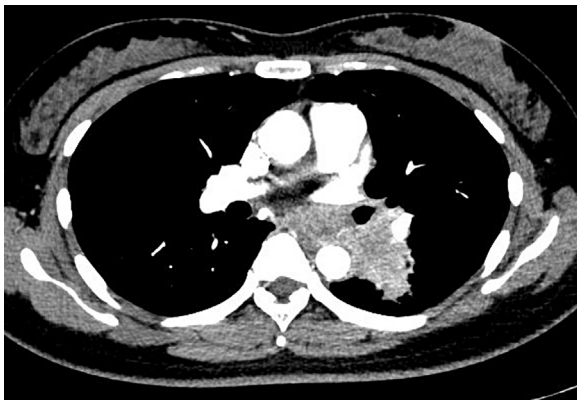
Enhanced computed tomography scan performed at the time of hospitalization revealing a mass in the left lung.
